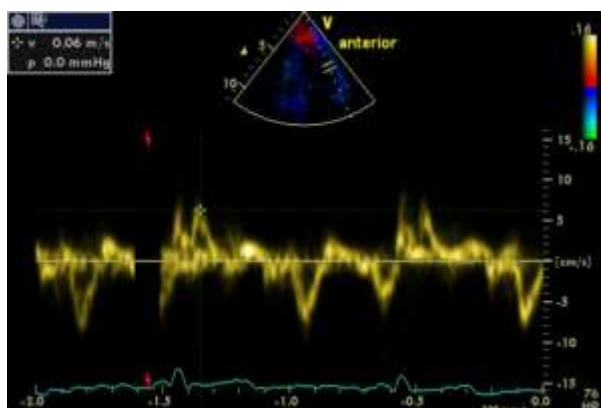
Systolic myocardial velocity measured by PW-based tissue Doppler imaging at the mid-anterior wall in two-chamber view
